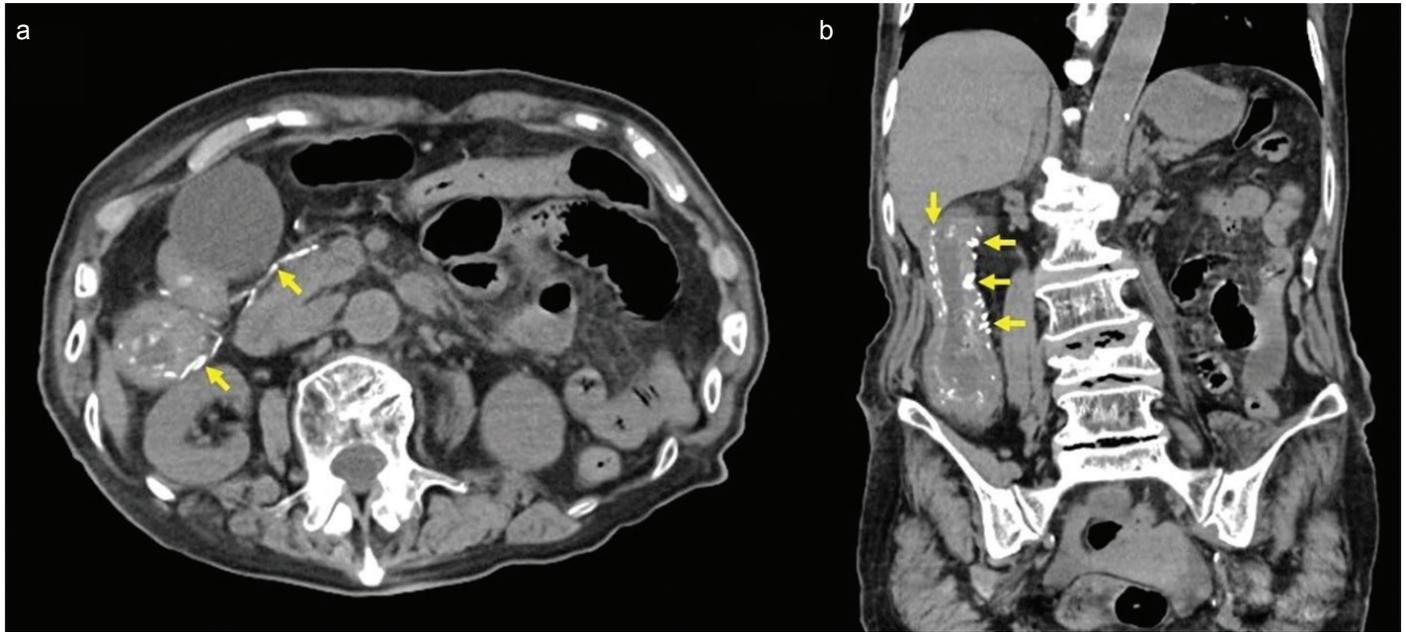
Non-enhanced computed tomography revealing calcification of the mesenteric veins (arrows) and thickening of the wall of the ascending colon (a, axial view; b, coronal view).
